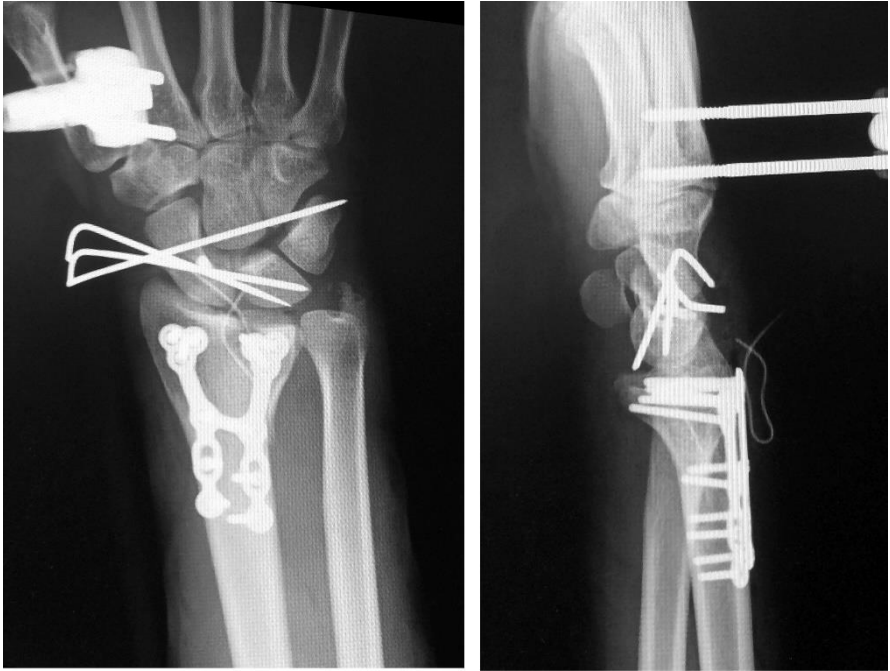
Posteroanterior and lateral radiographs taken after the patient was treated using internal fixation with dorsal distal plating (Aptus® 2.5 TriLock Distal Radius Plates, dorsal) and a radiocarpal external fixator. The scapholunate ligament was repaired with a suture anchor simultaneously via a dorsal approach.
